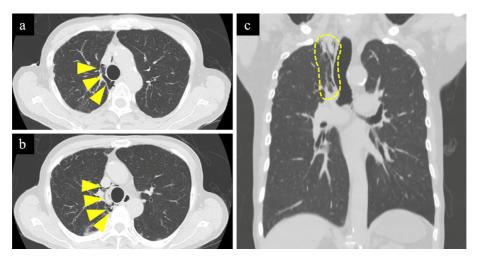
CT on the day of the hospital visit (day 0). a) Axial view: Lower thoracic esophagus. Mediastinal emphysema could be identified (yellow arrowheads); no findings near the EG junction suggested any perforation. b) Axial view: The mediastinal emphysema extended into the middle thoracic esophagus (yellow arrowheads). c) Coronal view: Mediastinal emphysema was present almost evenly over the entire esophagus (yellow dotted line frame).
